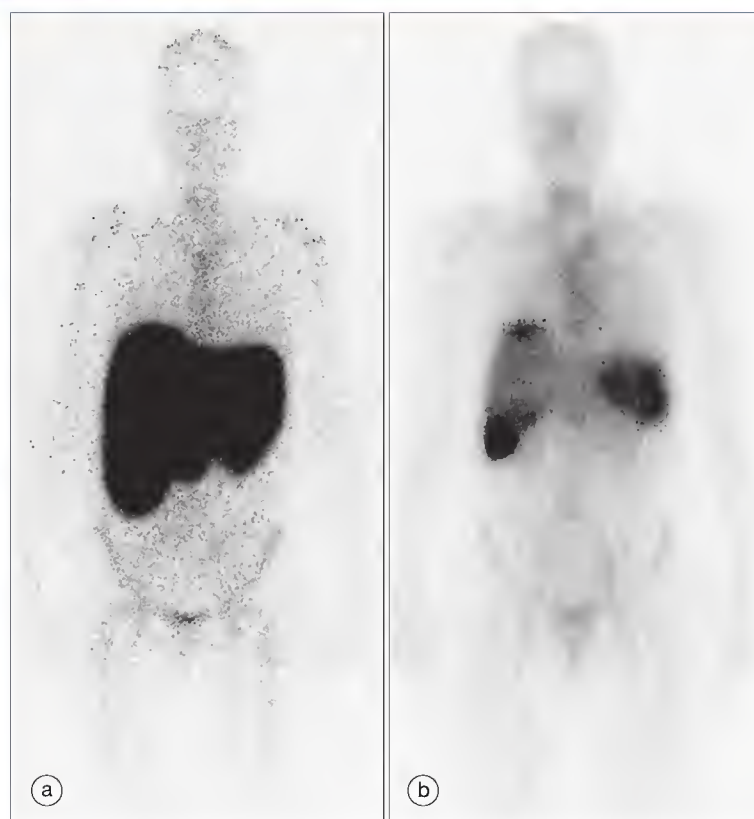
Anterior whole-body radiolabeled serum amyloid P component (SAP) scintigraphs demonstrating regression of AL amyloid deposits following chemotherapy. (a) At diagnosis the SAP tracer localized to AL amyloid deposits in the liver, spleen, and bones of this patient, who had hepatomegaly at presentation. (b) A follow-up scan 5 years later following successful chemotherapy shows that there has been regression of amyloid in all sites, most marked in the liver, which has returned to a normal size.
